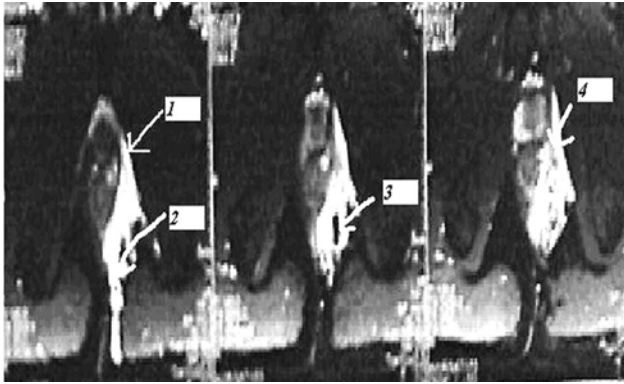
MRI by endo rectal coil. Arrows no. 1 and 4 refer to supralelevator abscess that was missed during initial surgery while no. 2 and 3 refer to extrasphincteric tract ends by sinus.
